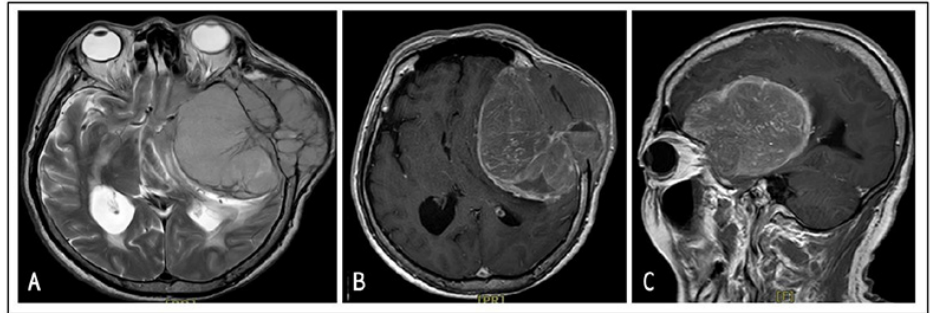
A: Axial T2-weighted brain magnetic resonance; B: Axial T1-weighted brain magnetic resonance imaging with intravenous contrast; and C: Sagittal T1-weighted brain magnetic resonance imaging with intravenous contrast showed a 10 x 9.6 x 8.6 cm lobulated homogenous mass at the left temporal region which obliterated the calvaria and destroyed the bones.
